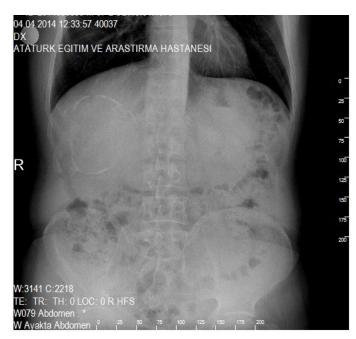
Abdominal X-ray imaging showing a curvilinear calcification on the right upper abdominal quadrant.
